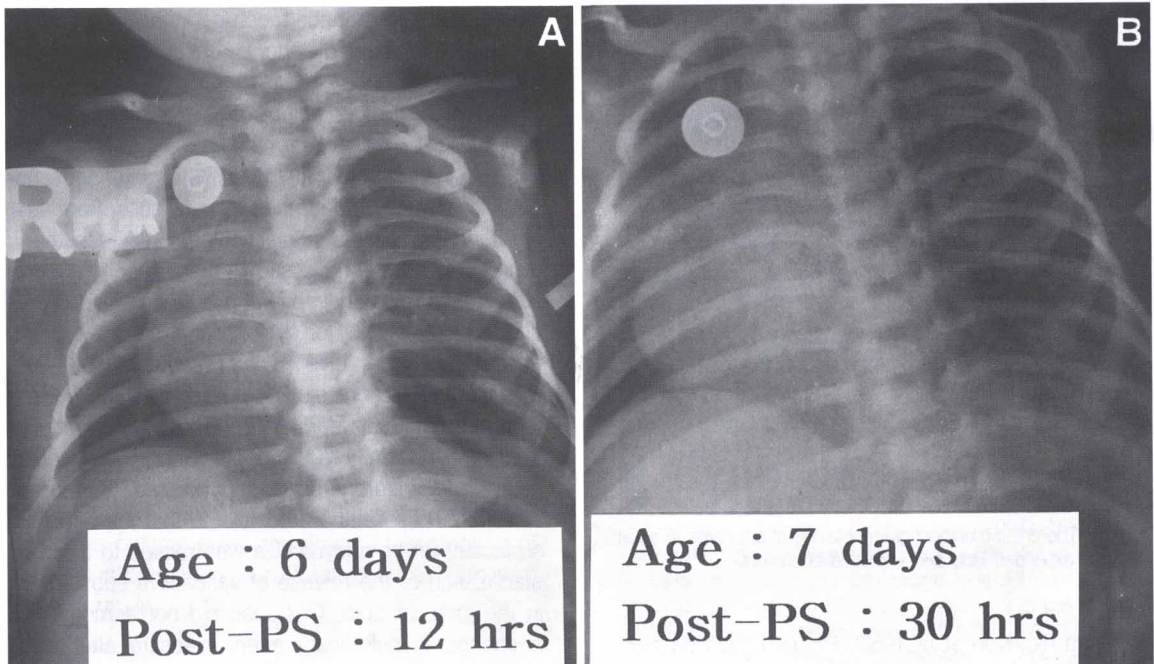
The chest roentgenogram obtained at 12 hrs (A) and 30 hrs (B) after surfactant administration respectively showed a much expanded left lung and nearly corrected displacement of the heart and mediastinum.
